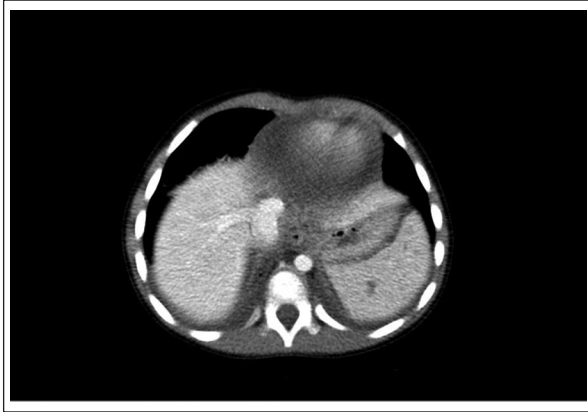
Computed tomographic scan demonstrating lucencies in the spleen and pericardial effusion
